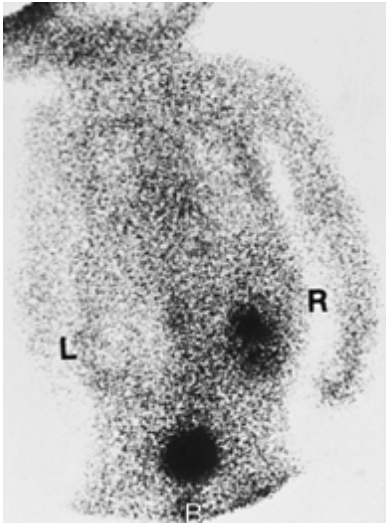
26. Boy, 3 days old, with cystic left kidney on ultrasound. ^{99m}Tc glucoheptonate study demonstrates a normal right kidney and a photon-deficient area in the region of the left kidney that remained photopenic, compatible with a multicystic kidney. Bladder activity (*B*) was evident on this delayed static image.
